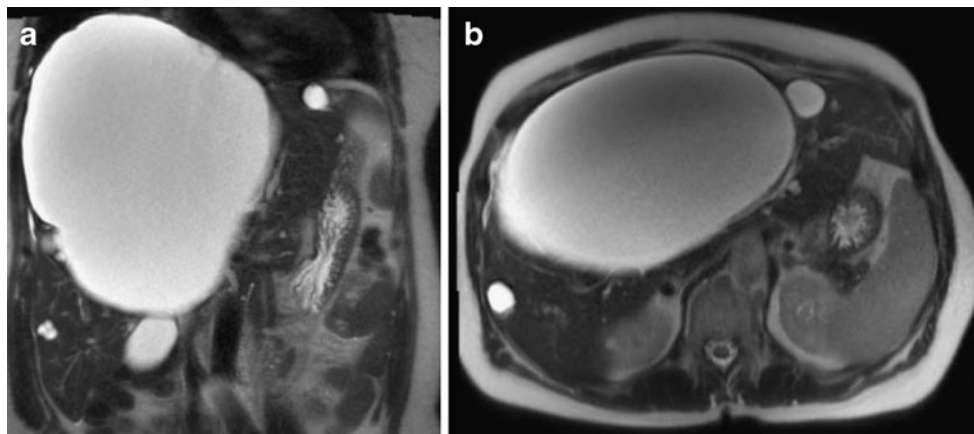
Large, uncomplicated cystic bile duct hamartoma; coronal (a) and axial (b) single-shot T2-weighted images demonstrate a large hepatic cyst expanding the right hepatic lobe. The cyst shows small lobulations, simple internal fluid and a thin peripheral rim of enhancement on coronal and axial postcontrast 3D gradient echo
